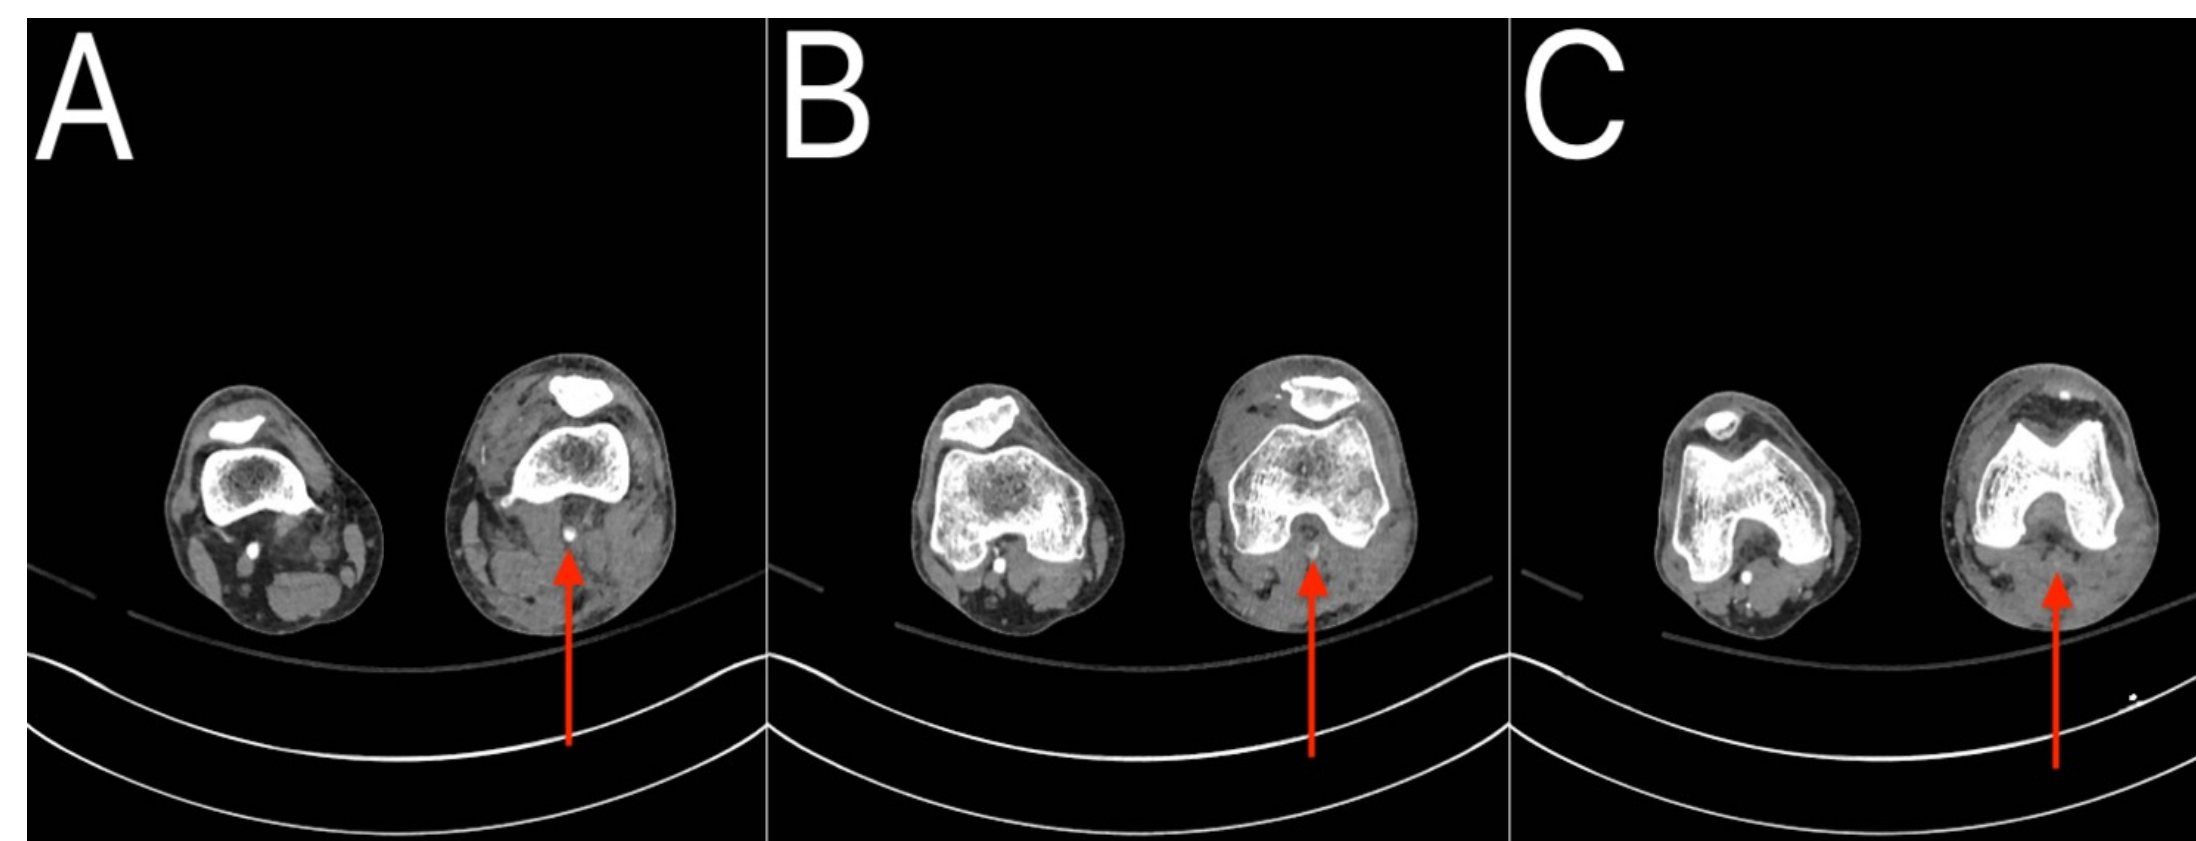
CT Angiography of lower extremities. (A) Complete patency of the popliteal artery is appreciated above the knee (B) High level of occlusion of the popliteal artery is appreciated at the knee (C) Complete occlusion of the popliteal artery is below the knee
